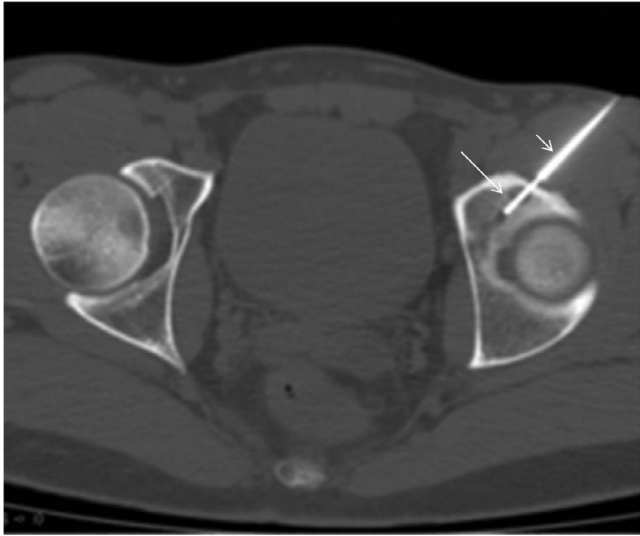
Computed tomography image during the second ablation procedure shows the active tip of the radiofrequency electrode (long arrow) inside the nidus of the OO advanced coaxially through the bone drilling needle (short arrow)
